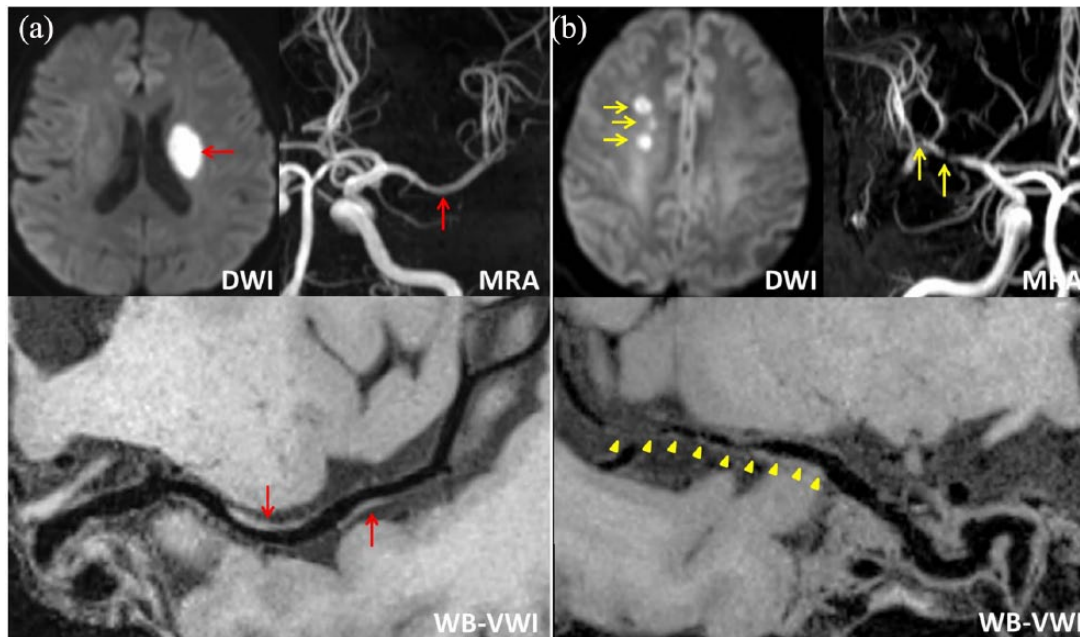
Representative cases of deep-perforator infarction (DPI) (a) and non-DPI (b). (a) Diffusion-weighted imaging (DWI) with a high signal intensity lesion (red arrow) in the left basal ganglia, magnetic resonance angiography (MRA) with mild stenosis in the left middle cerebral artery (MCA) (red arrow), whole-brain vessel-wall imaging (WB-VWI) revealing focal plaques (red arrows) in the left MCA. (b) DWI showing multiple high signal intensity lesions (yellow arrow) in the right centrum ovale, multiple severe stenosis of the right MCA (yellow arrows) by MRA, WB-VWI with diffuse plaques in the right MCA (yellow arrowheads).
